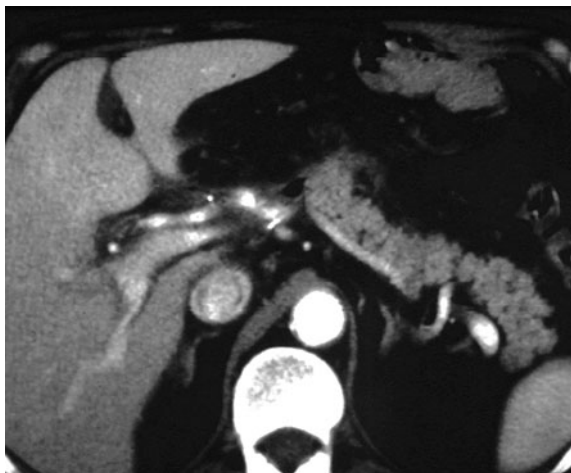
Postoperative CT 3 days after a Whipple procedure in a 75-year-old man. Presence of a transient fluid collection with a small amount of gas
